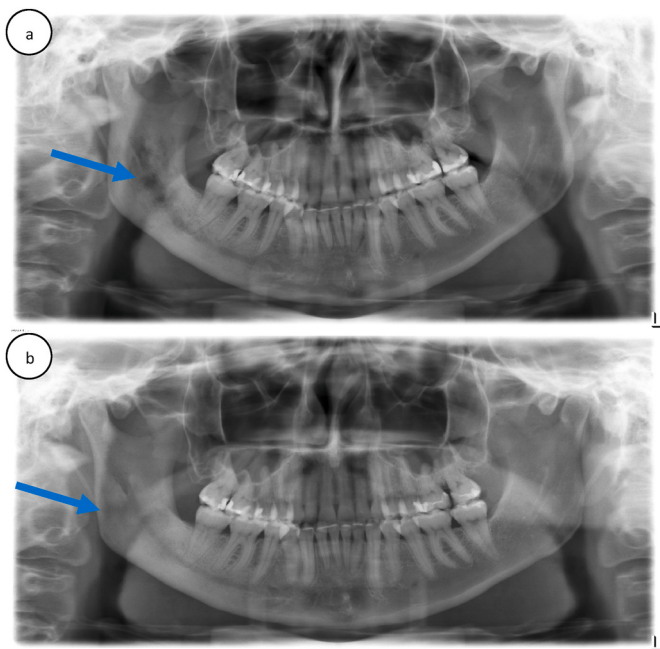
Panoramic radiograph of a 25-year old female patients with DSO left side a) Patient before administration of ibandronate 6 mg in an acute pain episode (osteolytic remodeling zones and blurred nerve canal) b) Patient 6 months after administration of one dose ibandronate 6 mg (reduced bone remodeling zones and increased sclerotic areas).
